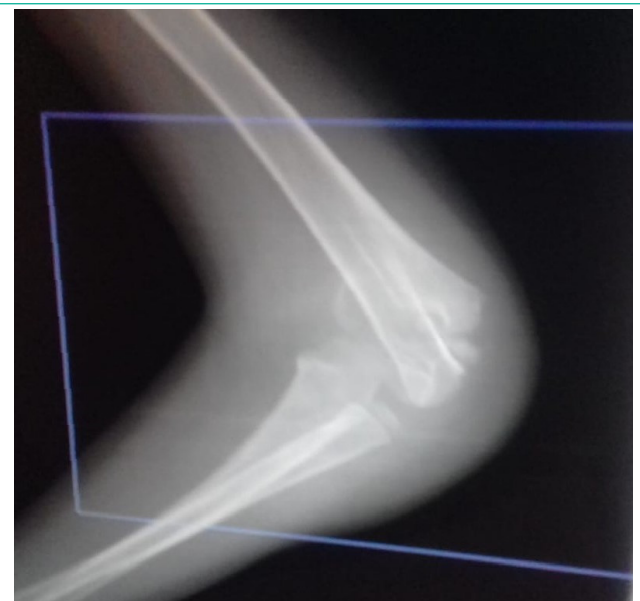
Side X-ray of the elbow showing anterior elbow dislocation with olecranon fracture.
